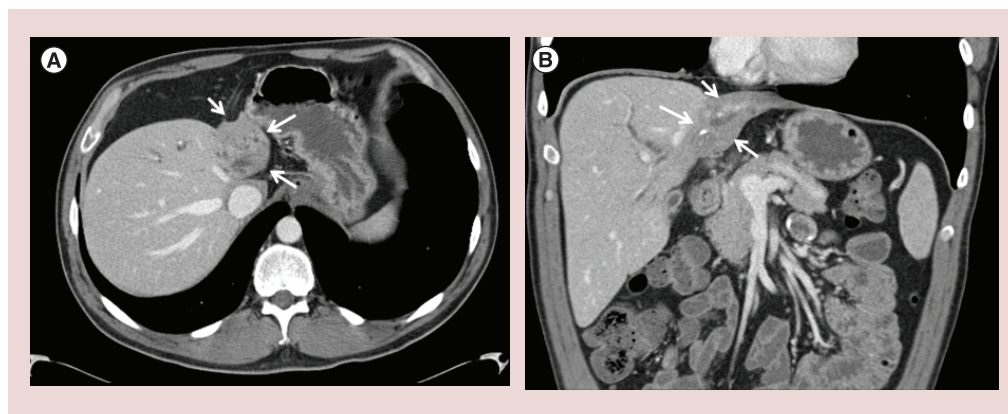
Axial and coronal CT images demonstrating the ‘atrophy-hypertrophy complex’ in a patient with perihilar cholangiocarcinoma. (A) Axial section demonstrating marked left lobe atrophy as highlighted by the arrows. (B) Coronal section demonstrating atrophy of the left lobe due to vascular involvement by tumor and compensatory hypertrophy of the unaffected right lobe.
